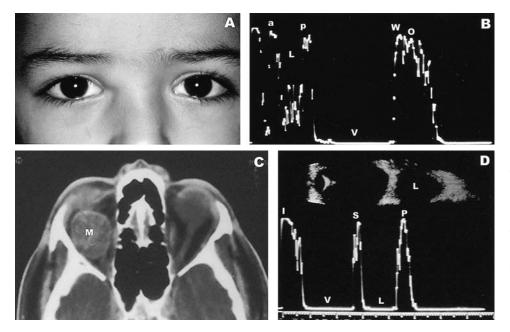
Cystic lesions (A,B) dermoid cyst and (C,D) hematocele. (A) Clinical photograph of a child with right anterior, medial orbital mass. (B) Transocular A scan shows an anterior low reflective lesion (L) shown within smooth high reflective echo spikes that delineate the anterior (a) and the posterior (p) wall of the cystic structure. V, vitreous cavity; W, ocular wall spike; O, orbital tissue spikes. (C) Axial CT scan shows well-delineated round mass (M) in the right orbit. (D) B scan (top) displays a round echolucent orbital lesion (L). A scan (bottom) shows low reflectivity of the lesion (L) with high posterior surface spike (P) from the cyst wall. Occasionally, there are moderately high reflective, dispersed spikes representing lines of clotted blood. I, initial spike; V, vitreous cavity; S, sclera or ocular wall; O, orbital tissue
